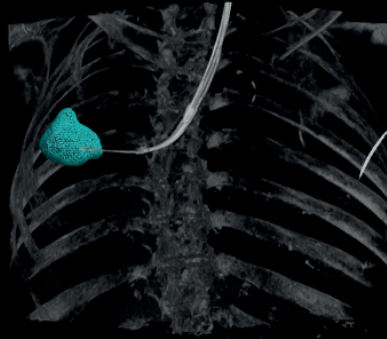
Coronal cone beam CT (left) and 3D (right) confirmation of accurate lesion targeting.
